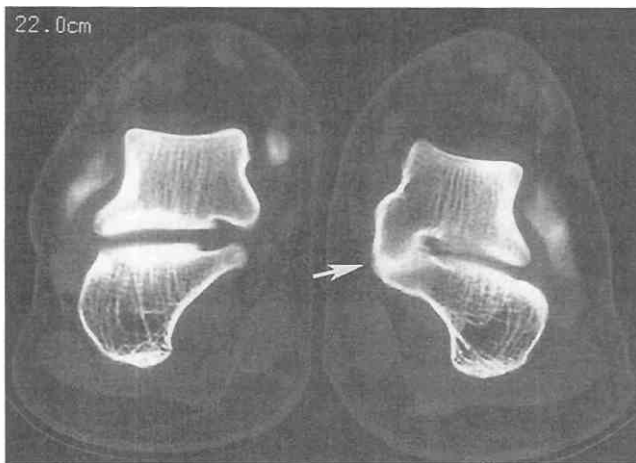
Tarsal coalition in a 15-year-old boy. The direct coronal CT image shows osseous continuity of the left talus and calcaneus at the middle talocalcaneal joint (arrow). The right side is normal.
